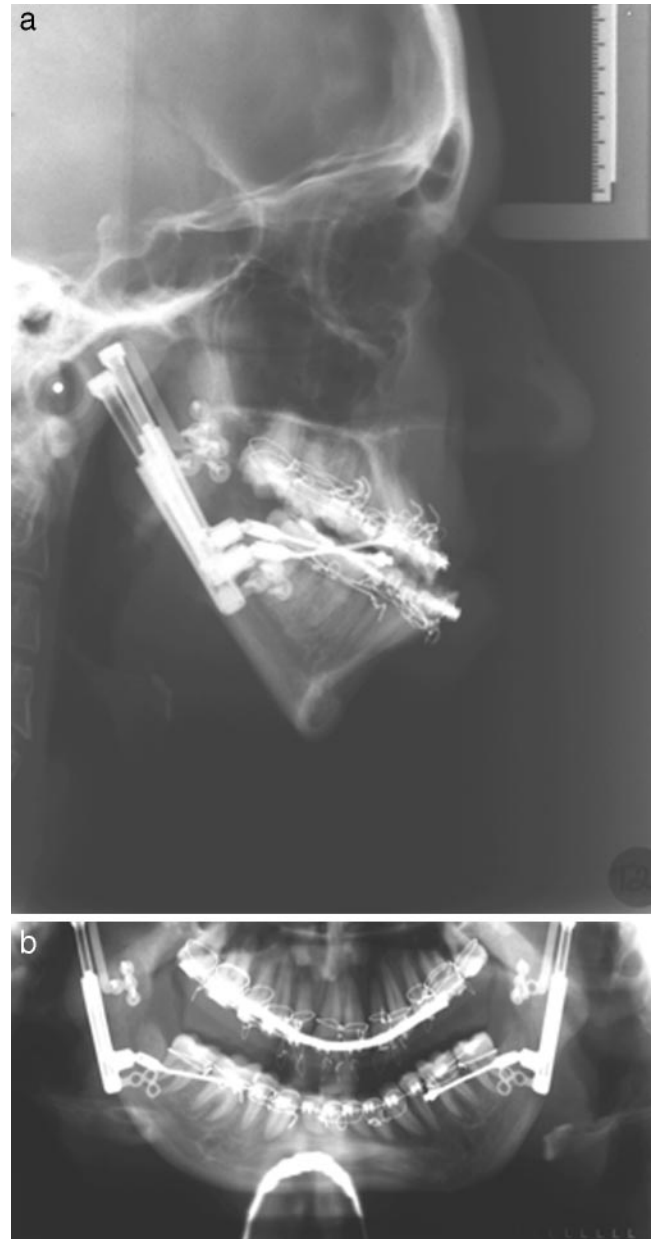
(a) Lateral cephalometric radiograph at the end of distraction. (b) Progress orthopantomogram. Note developing regenerate in distraction region.
